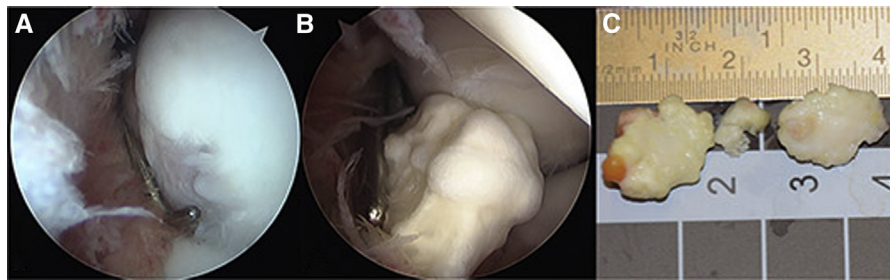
Arthroscopic images from a 17-year-old baseball pitcher with persistent elbow pain and a large osteochondritis dissecans (OCD) demonstrated on preoperative radiographs and magnetic resonance imaging. Diagnostic arthroscopy demonstrated (A) a large OCD and (B) several loose bodies, (C) which were removed.
